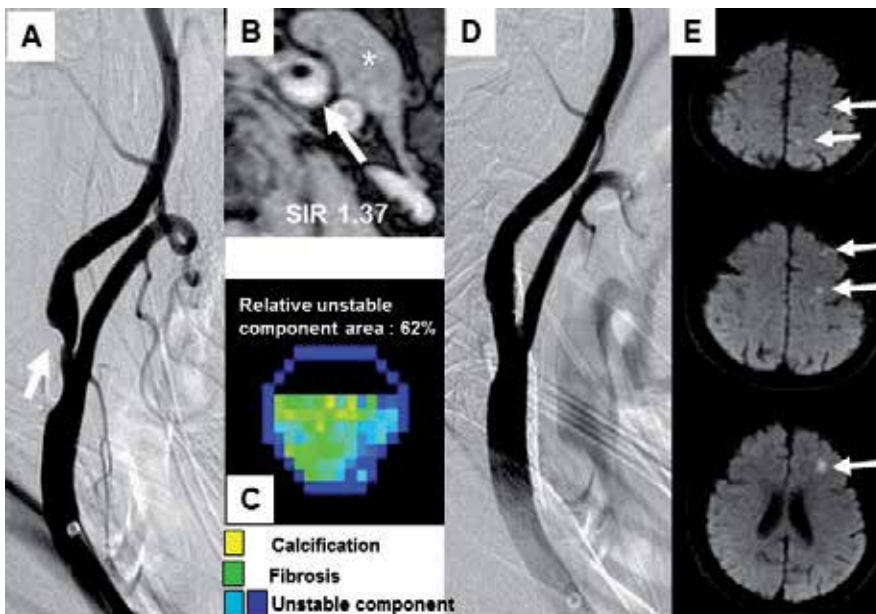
Representative images of CAS for an internal carotid plaque that consisted of less unstable component. (A) Pre-stenting angiogram of the left internal carotid artery stenosis. (B) White arrow: Axial image of the most stenotic lesion of the plaque on T1WI of BB-MRI. *: sternocleidomastoid muscle. The SIR was 1.37 (C) Cross-sectional color-coded map of the most stenotic lesion of the plaque on IBS. Relative unstable component area was 62%. (D) Post-stenting angiogram of the left internal carotid artery stenosis. After carotid artery stenting, the lumen of the right internal carotid artery was successfully dilated. (E) Diffusion-weighted magnetic resonance imaging. White arrows: multiple silent ischemic lesions are detected in the left cerebral hemisphere after the post-stenting procedure.
